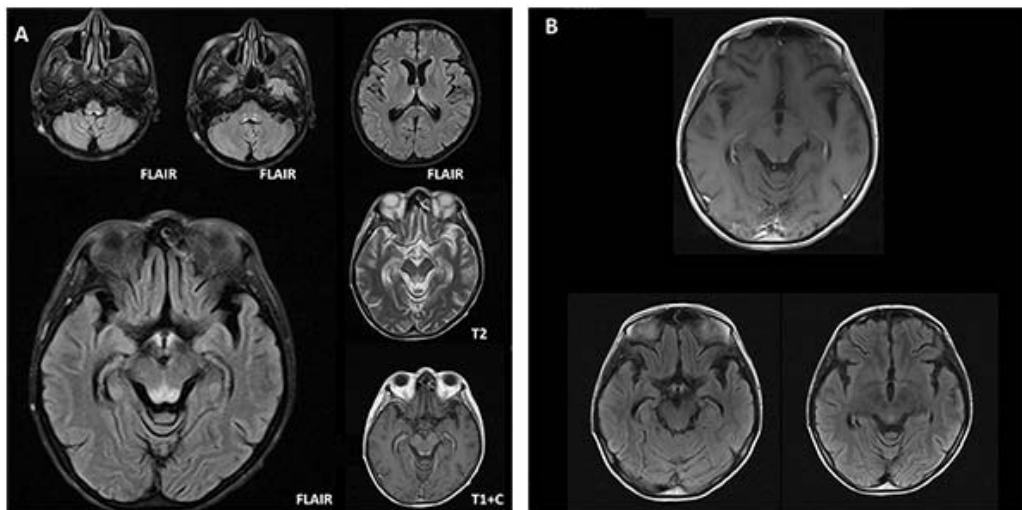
Bilaterally symmetrical hyperintensities in medial thalami, periaqueductal area, bulbus and mamillary bodies on T2WI and FLAIR . Figure 1B: Follow-up MRI showed resolution of abnormal signals and contrast enhancement .
